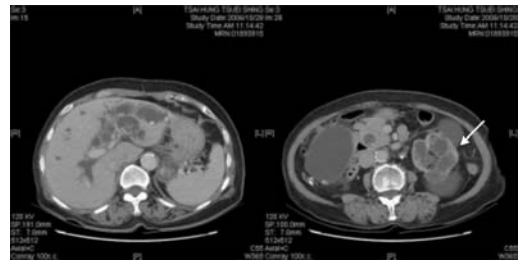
Contrast-enhanced abdominal CT showing left IHD dilatation with multiple stones in situ and multiple irregular cysts in the left kidney (arrow).
